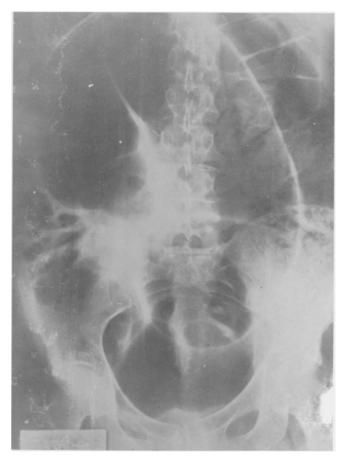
X-ray of the abdomen showing acute sigmoid volvulus (Case 3).
